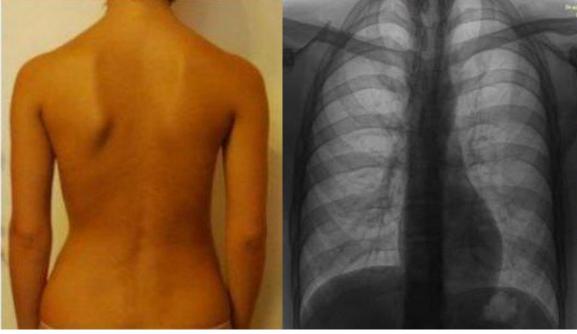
The constitution of patient N., 16 years old Fig. 2. Chest X-ray
